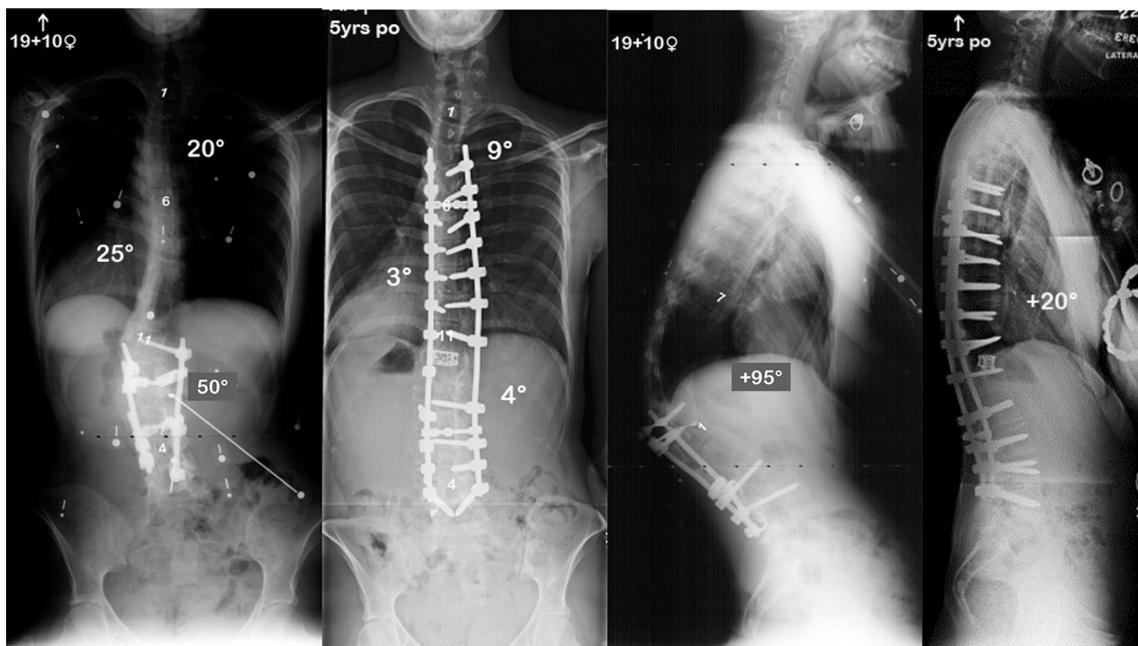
Comparison pre- and postoperative X-rays s/p a T12 VCR and PSF from T5–L5 showing restoration of normal alignment maintained 5 years after surgery
